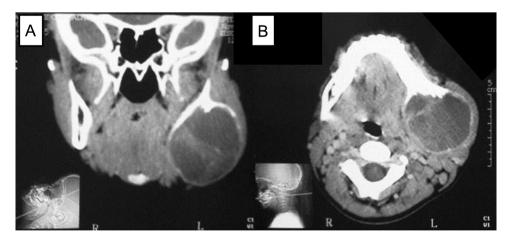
Computed tomography in coronal (A) and axial (B) sections showing an hypodense area of approximately 8 mm in its largest diameter in the mandibular angle and left mandibular body areas, well-defined margins, cortical bone expansion and solid-cystic component.
